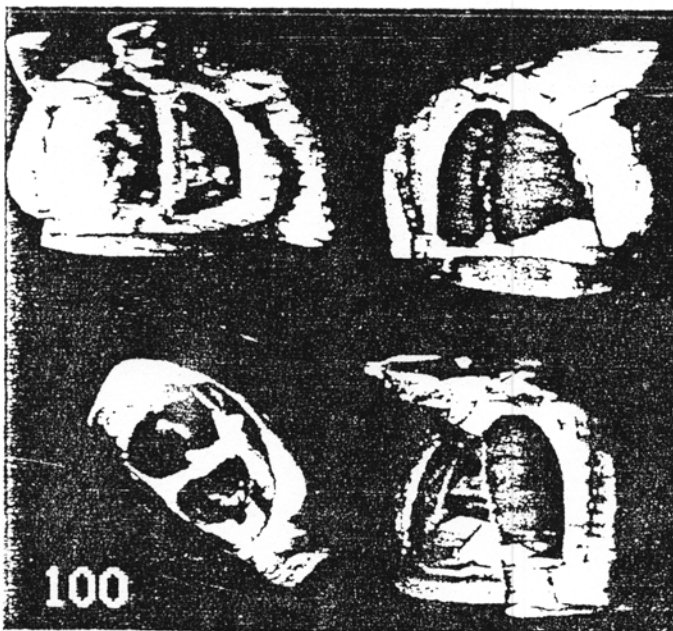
(a) The 100% isodose surface from a tangential beam setup for the treatment of breast cancer (pink). Shown are an AP, posterior oblique, transverse and lateral view. The white object in the center of the lower left image is the underside of the patient's head and nose. (b) The 135% isodose surface of the same set up as in Fig. 3a. Notice the unexpectedly "ragged" distribution of dose seen in the upper left hand view. Such a distribution would be hard to understand if displayed only on conventional CT slices.
